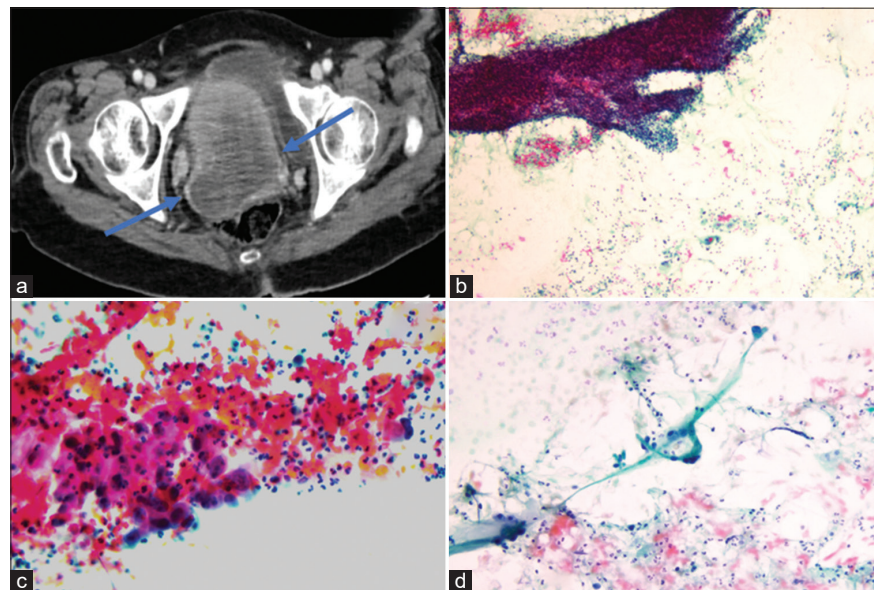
(a) Contrast-enhanced computed tomography scan axial image at the region of the pelvis showed a large heterogeneous enhancing mass occupying the uterus and protruding into the upper vagina (arrows). (b) Cytological cervical smears examination showed tissue fragments of round to oval hyperchromatic nuclei with scant cytoplasm in necrotic debris background (Pap, ×10). (c) Cells with abundant granular to glassy cytoplasm and nuclei with coarse irregularly distributed chromatin and macroprominent nucleoli (Pap, ×40). (d) Large bizarre cells with strap-like, rhabdoid morphology (Pap, ×20).
